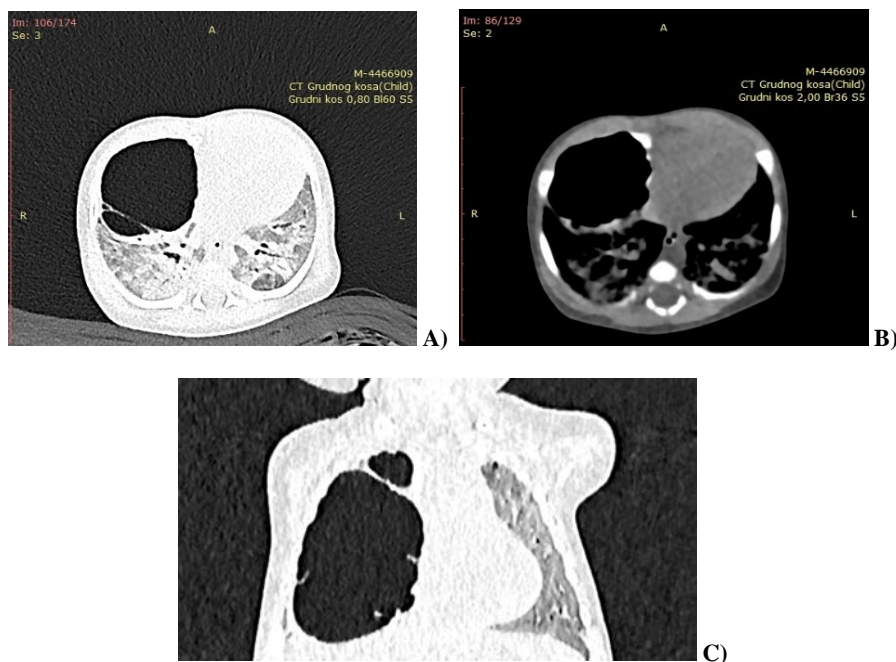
Computed tomography of the chest. Pneumatocele observed in transverse (A and B) and coronal plane (C).
